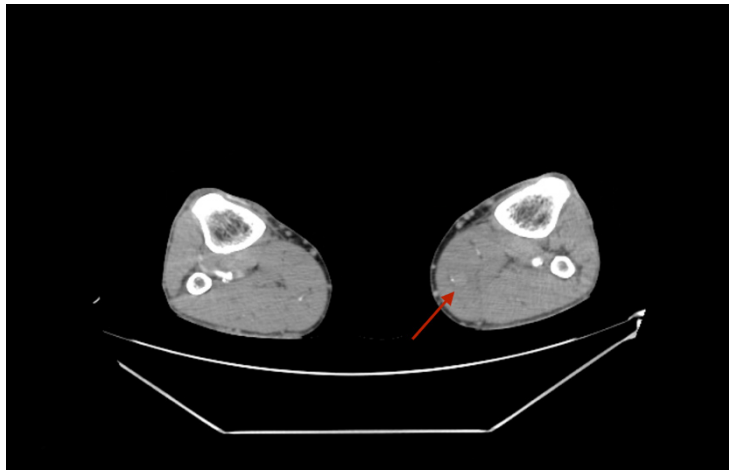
Absence of contrast filler in venous phase in the posterior tibial vein on CT angiography
